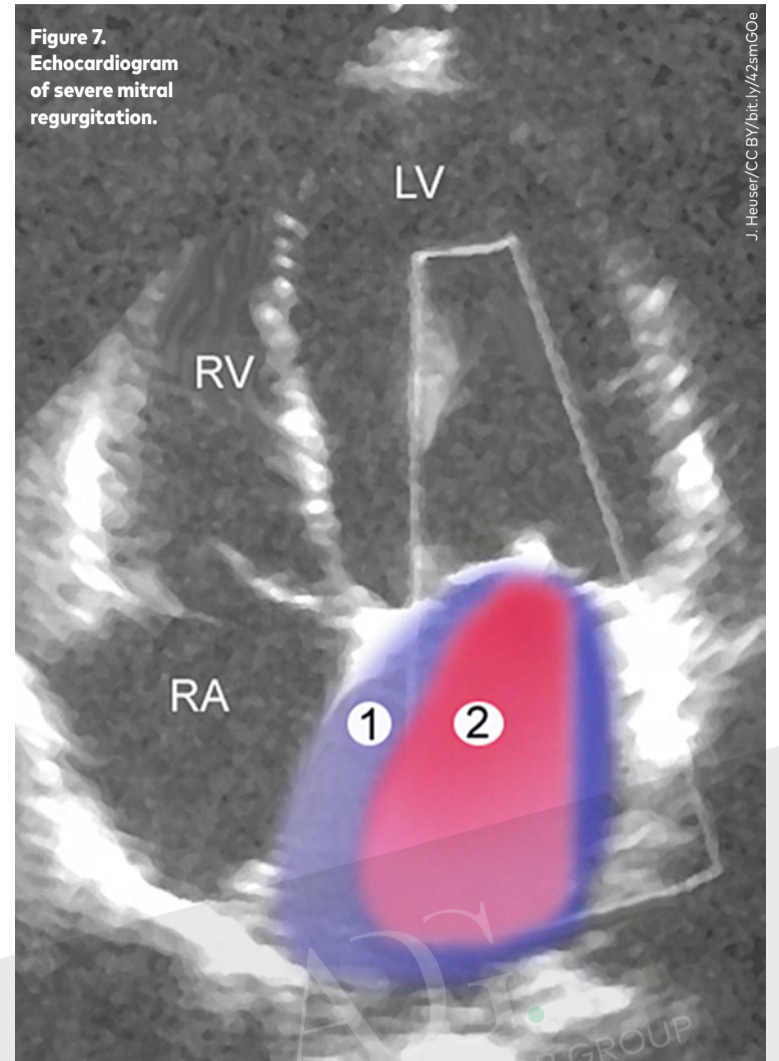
Echocardiogram of severe mitral regurgitation.
